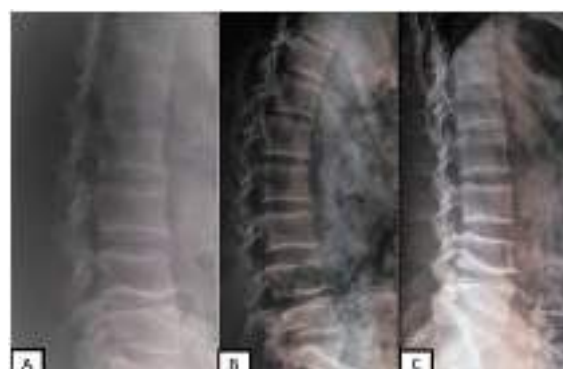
The conventional lateral radiograph of one of our samples (A) shows osteophytes in the vertebral body and there is no spondylolisthesis. On the flexion (B) and extension (C) lateral radiographs, there is posterolisthesis at the level of L4-5.
